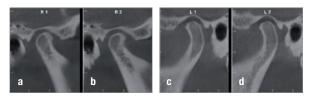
CBCT images of both temporomandibular joints after splint therapy (sagittal views). (a & b) Right. (c & d) Left.
